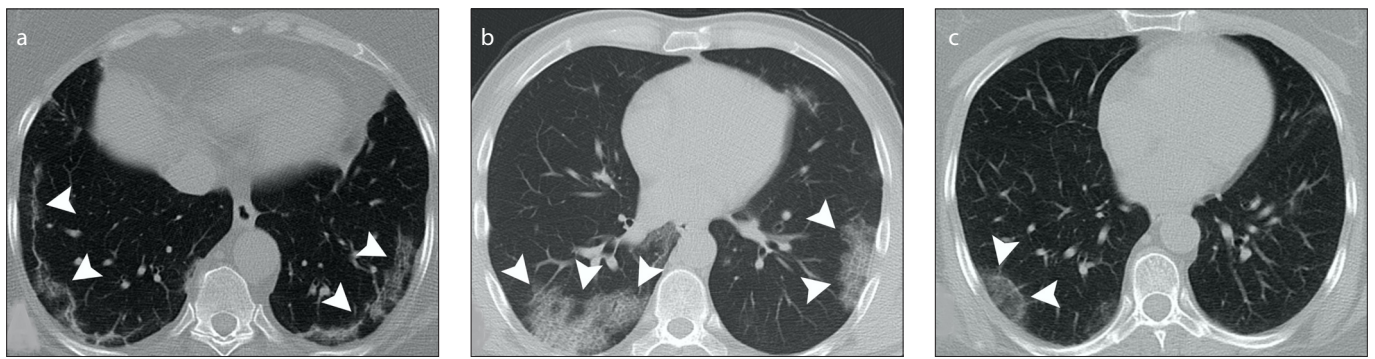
a–c. Axial low-dose chest CT image (a) of a 51-year-old female COVID-19 patient presenting with fever and dry cough for 3 days shows subpleural curvilinear lines (*arrowheads*) in the bilateral lower lobes. Axial low-dose chest CT image (b) of a 41-year-old male COVID-19 patient presenting with fever, cough, and fatigue for 5 days demonstrates a crazy-paving pattern in the bilateral lower lobes (*arrowheads*). Axial low-dose chest CT image (c) of a 46-year-old female COVID-19 patient presenting with fever, dry cough, and myalgia for 3 days shows a peripherally placed reversed halo sign (*arrowheads*) in the right lower lobe.
